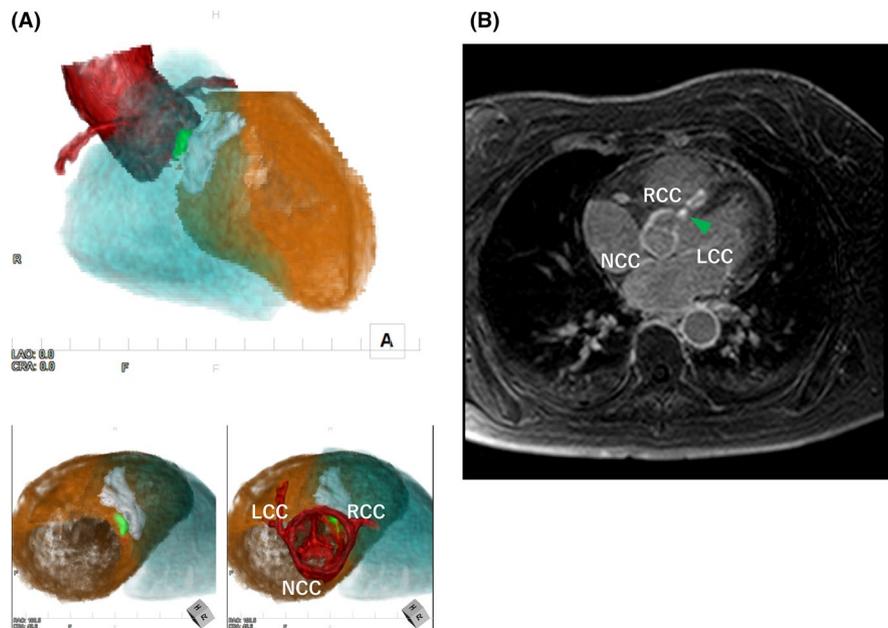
A, Three-dimensionally reconstructed Late gadolinium enhancement magnetic resonance imaging of the RV, LV, and ASC. The lower panel shows the LV ostium with and without the ASC in the cranial view. The late gadolinium enhancement area (RF lesion) is colored by light green. B, The RF lesion on the LGE-MRI. The light green arrowhead indicates the RF lesion at the myocardial crescent just beneath the ASC where the RF lesion extends from the myocardial crescent beneath the middle of the RCC to beneath the RCC-LCC junction. ASC, aortic sinus cusp; LAO, left anterior oblique; LCC, left coronary cusp; NCC, noncoronary cusp; RAO, right anterior oblique; RCC, right coronary cusp
